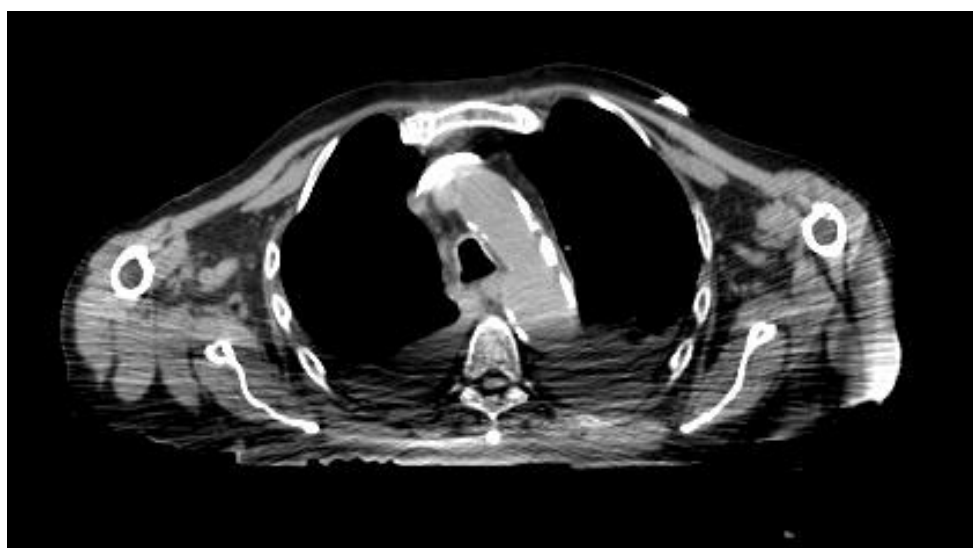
CT central section of figure 44
